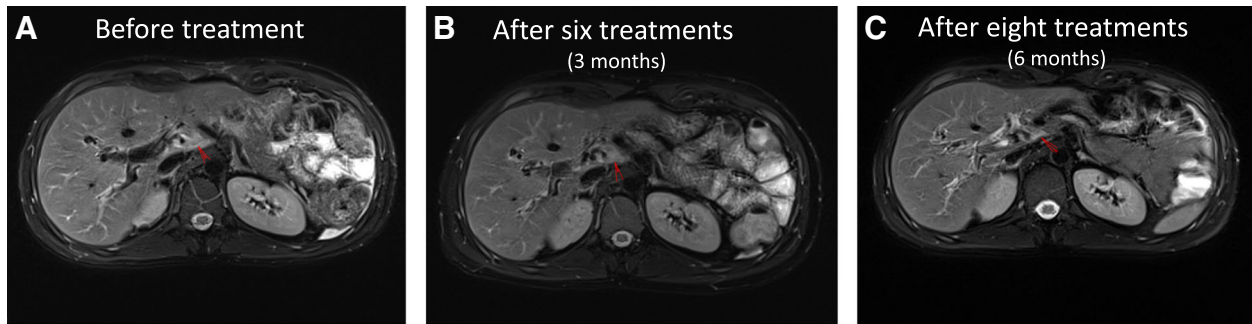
Upper abdominal MRI examinations were taken at 3 time points, a 2 weeks before treatment, b 3 month's clinical effect post treatment and c 6 months clinical effect post treatment. In this figure, we show representative MRI images obtained before entry into the clinical trial and after the 8th treatment course
